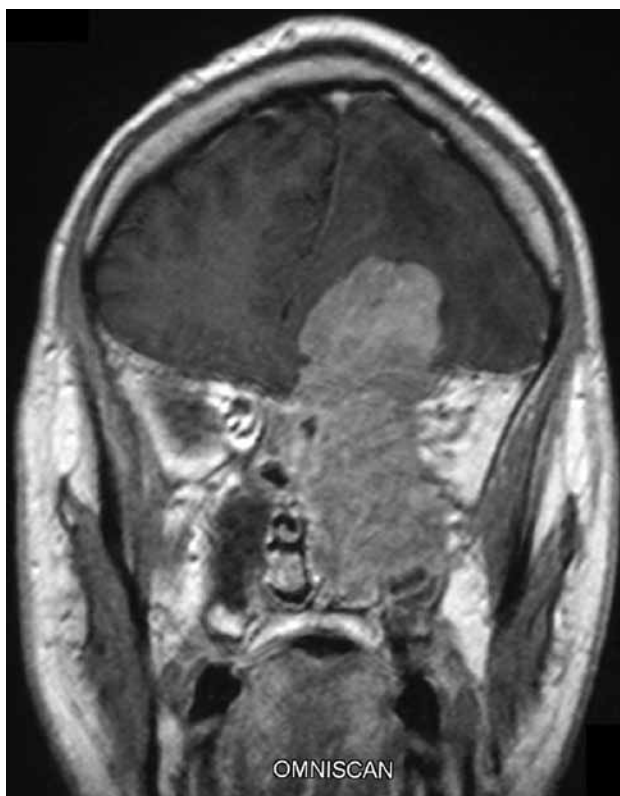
(original): Coronal T1-weighted MRI with gadolinium showing extensive intracranial extension of sinonasal undifferentiated carcinoma not amenable to endoscopic resection
